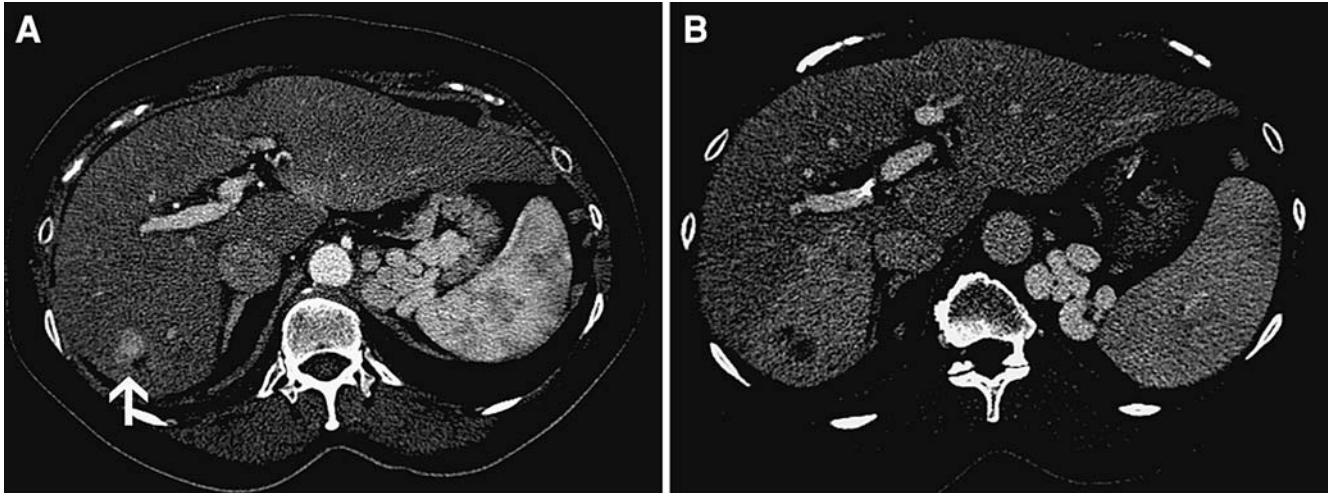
(A) Pre-treatment contrast-enhanced CT demonstrates a solitary segment VII posterior right lobe hepatoma (*arrow*) in a patient with portal hypertension and thrombocytopenia. Patient was a transplant candidate and therefore not
